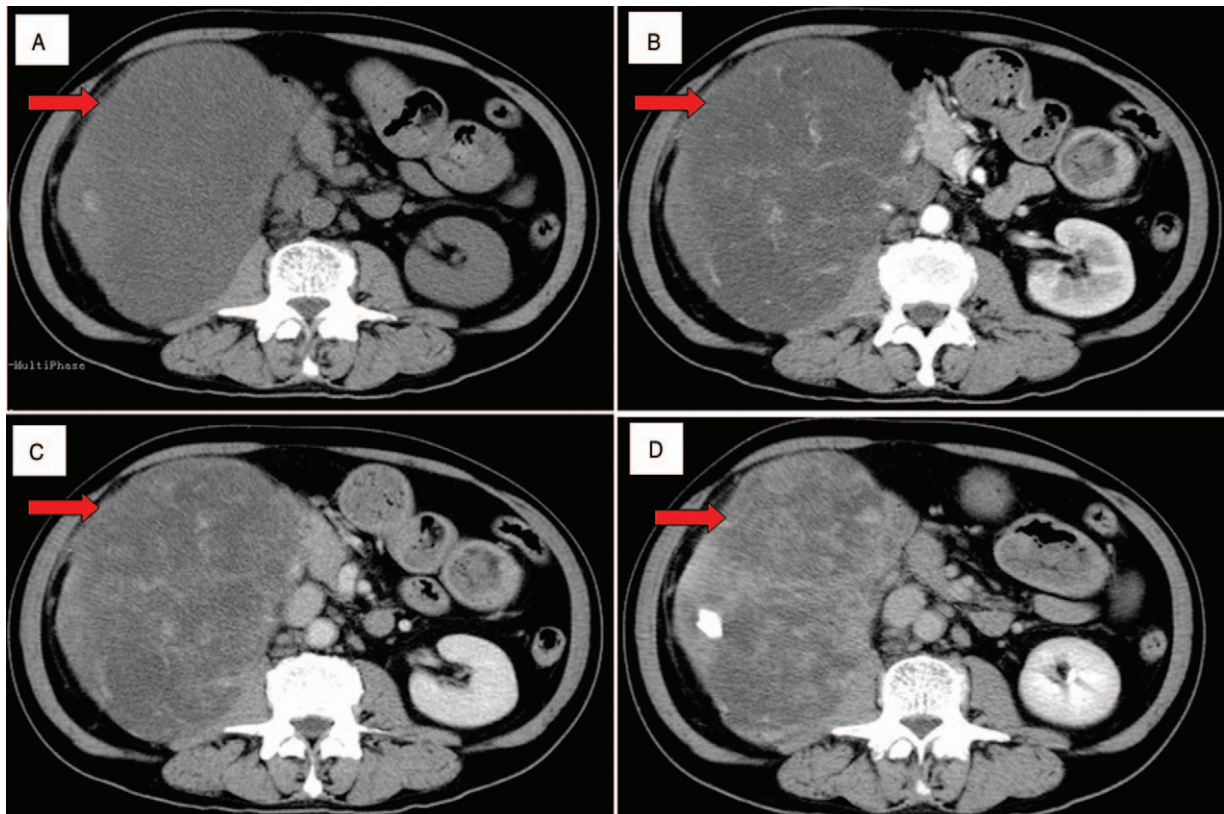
(A) Computed tomography image showing a heterogeneous, irregular, ill-defined boundary mass in the right kidney in the pre-contrast phase. (B–D) With contrast, the arterial, venous, and excretory phases show a solid, heterogeneous, and irregular enhanced mass in the right kidney.
